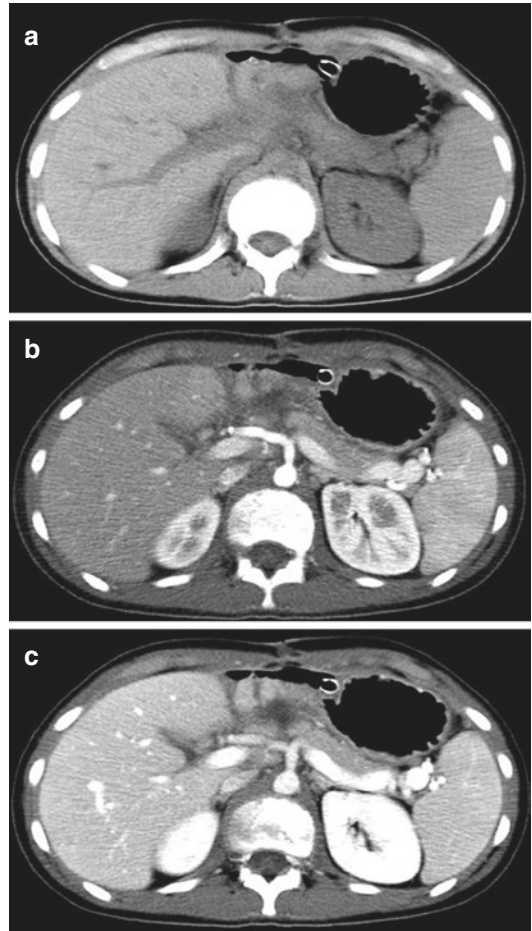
Unenhanced CT (a) and enhanced CT scan in arterial (b) and portal (c) phases show a case of pancreatic body transection. In unenhanced CT (a) there is an inhomogeneous aspect of the pancreas body; CE-CT scans (b, c) well detect the complete transection of the body as a hypodense linear image
